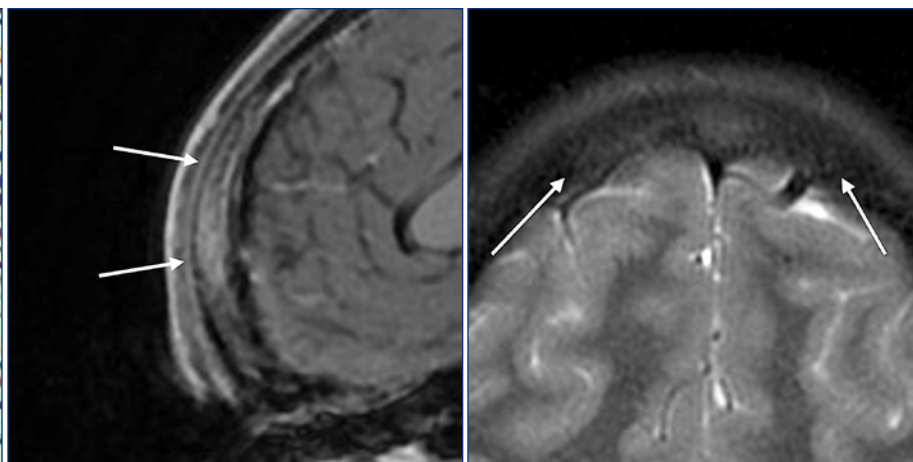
[A] Sagittal T1 post-contrast and [B] axial T2 fat suppressed MRI demonstrating decreased enhancement and osteitis six months later and post-treatment with antibiotics.
